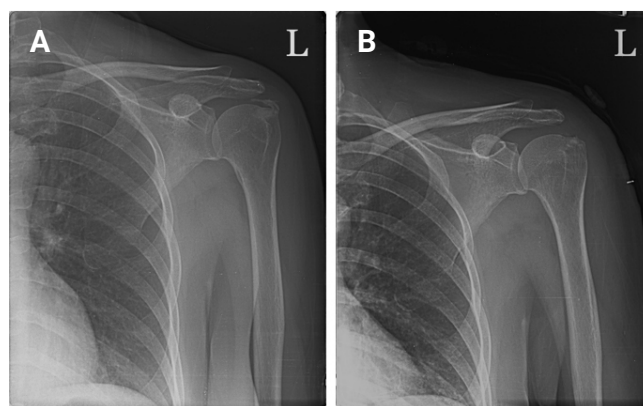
(A) A preoperative anteroposterior projection of the left shoulder reveals an amorphous calcification within the supraspinatus insertion area of the greater tuberosity. Note the presence of subchondral sclerosis in the greater tuberosity. (B) A postoperative plain radiograph showing near complete removal of calcium deposits.
